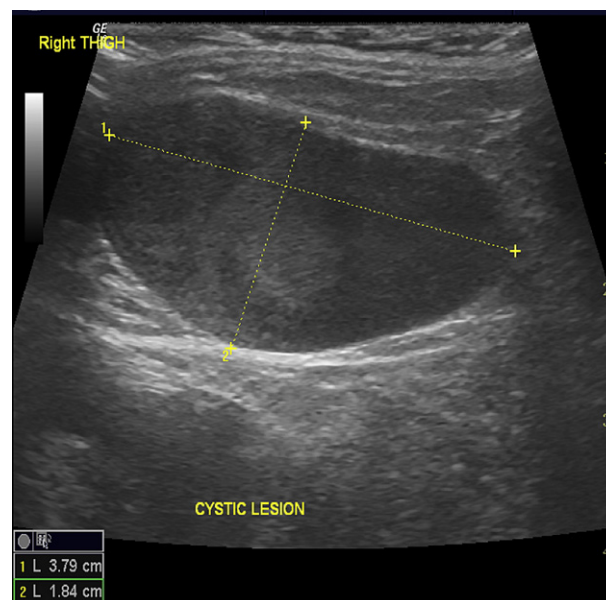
A sac-like fluid collection in the absence of Doppler interrogation.
